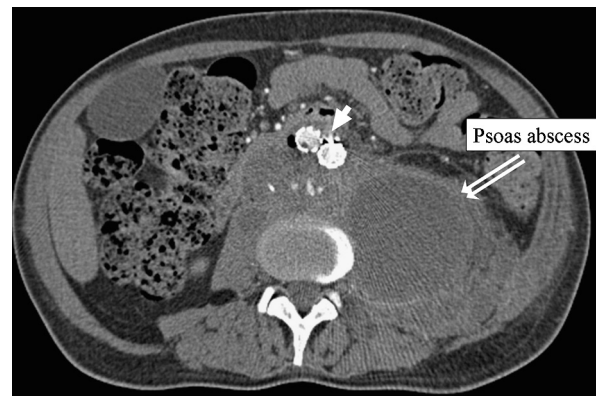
Computed tomography (CT) scan reveals periaortic fluid with gas bubbles (white arrow) and psoas abscess (double arrow) suggestive of infected aortic aneurysm.
